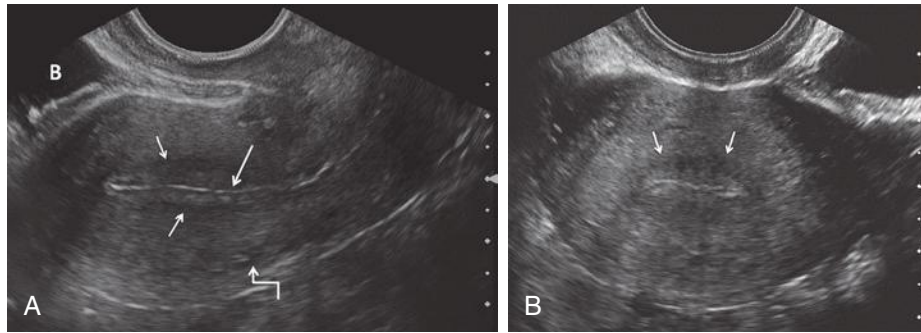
Transvaginal gray-scale ultrasound images of the normal uterus. A, Sagittal imaging plane. Note thin brightly echogenic line (*long arrow*) representing artifact or mucus between the echogenic anterior and posterior layers of the endometrium and the subjacent hypoechoic subendometrial halo (*short arrows*). The anechoic tubular arcuate vessels separating the outer from the intermediate layer of the myometrium are faintly visualized (*crooked arrow*). B, bladder. B, Transverse imaging plane. The hypoechoic subendometrial halo (*arrows*) can be seen surrounding the echogenic endometrium. Note significantly improved resolution and visualization of the normal zonal anatomy in these higher frequency transvaginal images in comparison to the lower frequency transabdominal images (Fig. 28-1). However, the transabdominal images have a larger field of view, providing a better overview of pelvic structures.
